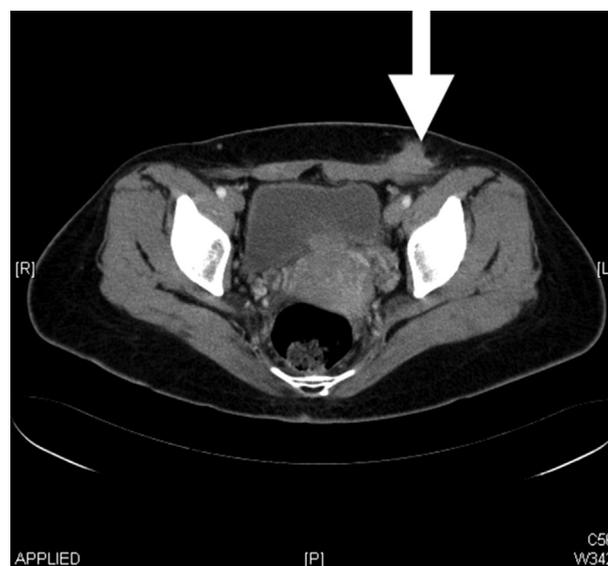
Computed tomography image shows anterior abdominal wall endometrioma measuring 2.9 cm.
